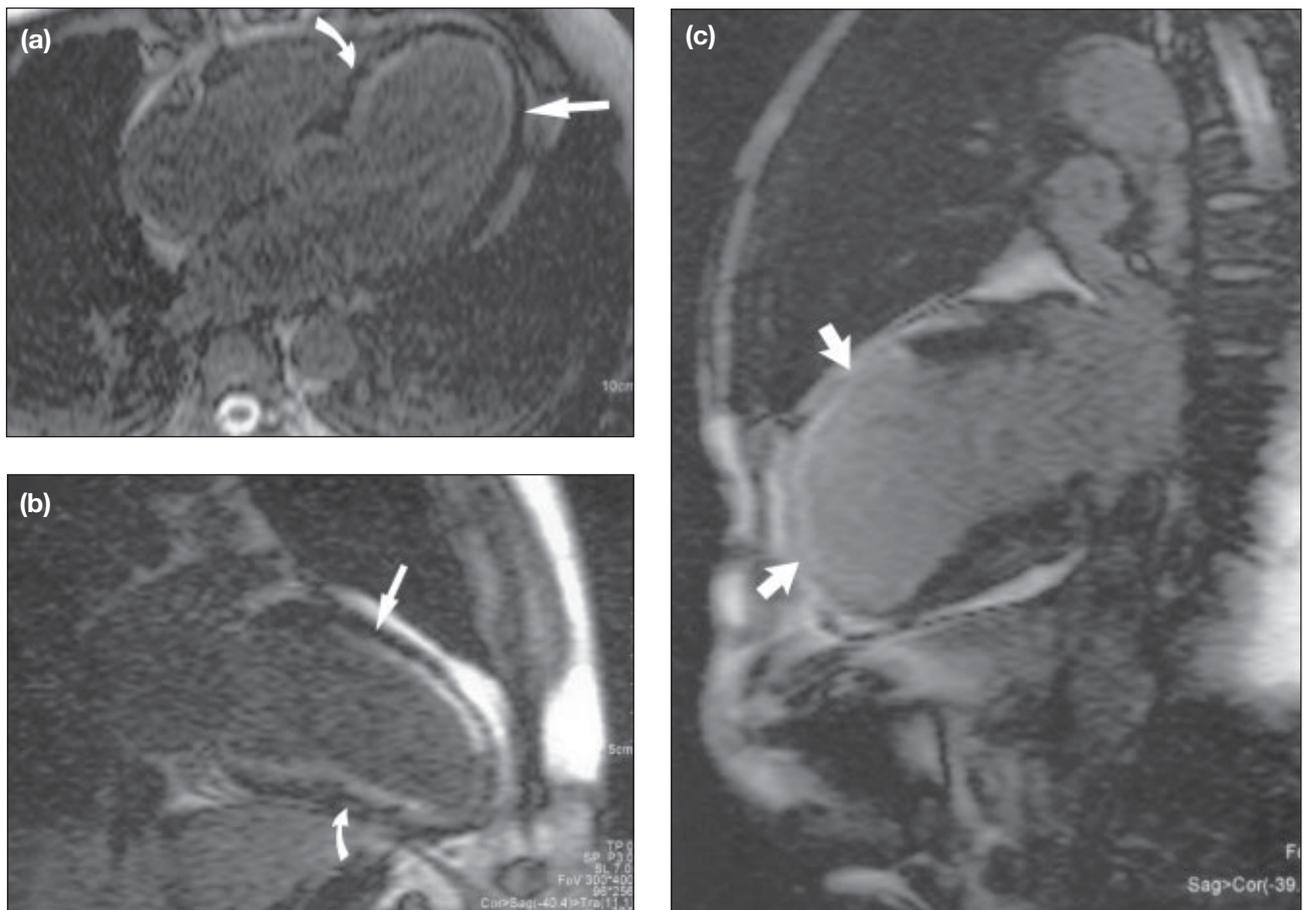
Magnetic resonance images: (a) four-chamber view shows non-transmural infarction of the lateral (arrow) and septal walls (curved arrow) of the left ventricle. About 50% of myocardial thickness shows enhancement representing myocardial infarction; (b) two-chamber view showing non-transmural infarction of the anterior (arrow) and inferior walls (curved arrow) of the left ventricle; (c) two-chamber view showing transmural infarction of the anterior wall of the left ventricle, extending to the apex (arrowhead)
